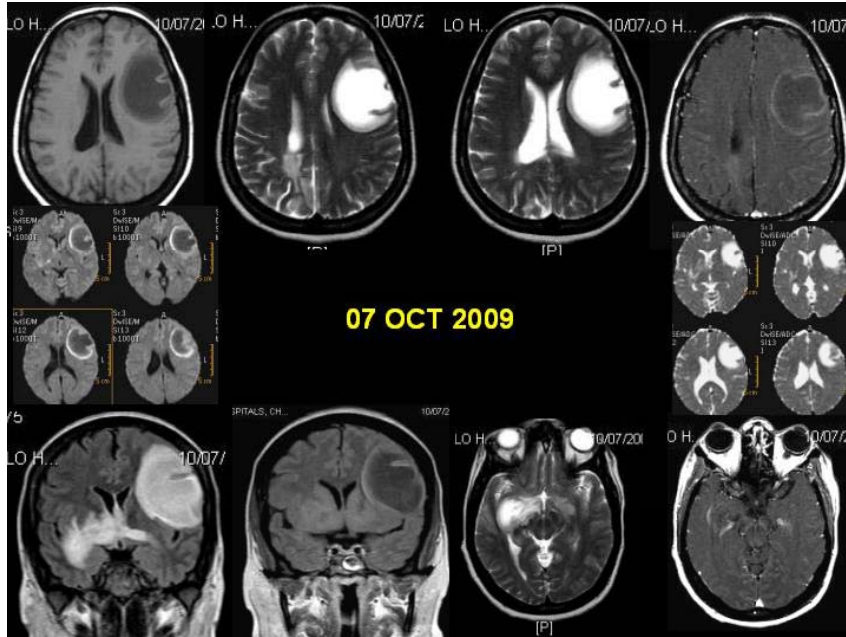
MRI shows two peripheral faint enhancing lesions with perilesional edema and mass effect in the left frontal and right temporal lobes; lesion reveals a peripheral rim of restricted diffusion on DW images suggesting neoplasm.
